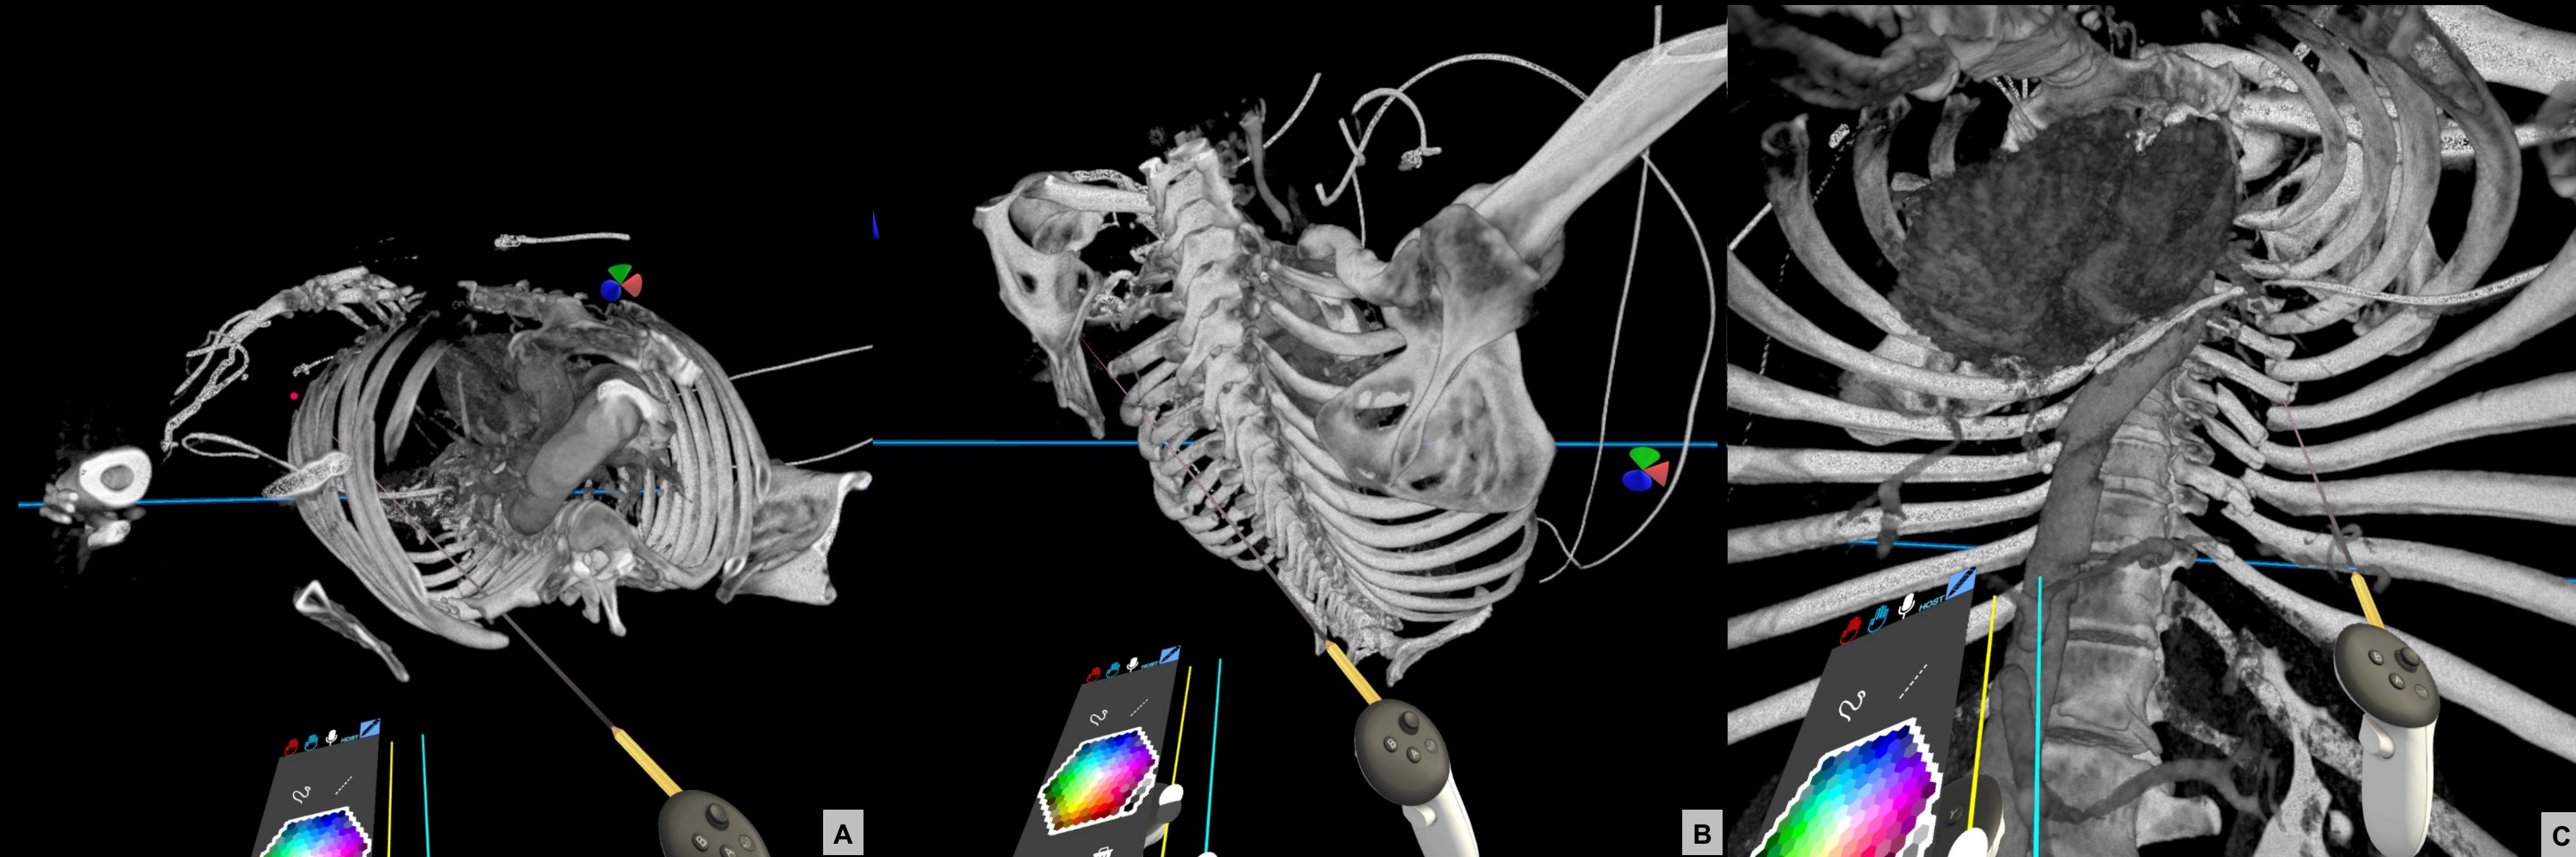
RibFracture_7 Chest CT with Virtual Reality - (A) cross sectioning; (B) posterior view; (C) internal view
